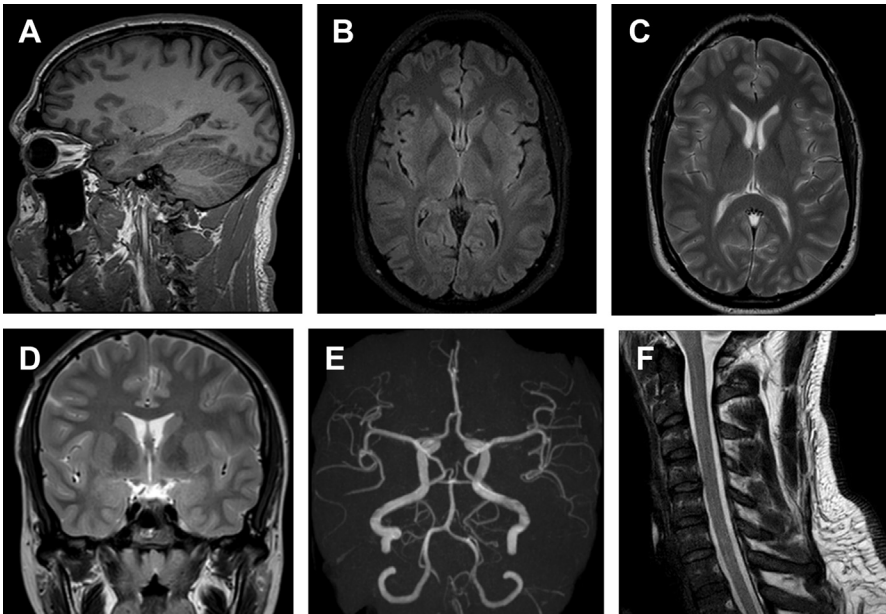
C-SENSE accelerated head and spine imaging in a rapid headache protocol on 3T. The total exam length is 16:07 min with the following individual scan times: sagittal 3D T1 (A): 3:37 min; axial 3D FLAIR (B): 4:00 min; axial 2D T2 TSE (C): 1:24 min; coronal 2D TSE (D): 1:26 min; 3D TOF MRA (E): 3:46 min; sagittal 2D TSE of the cervical spine (F): 1:54 min.
